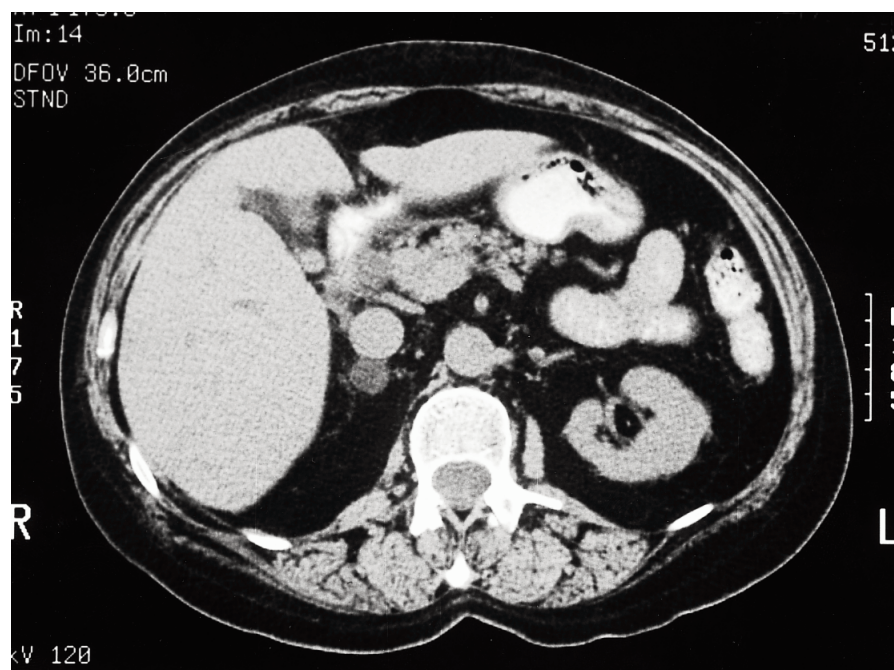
Adrenal CT scan from a patient (no. 27) demonstrating a 2-cm mass in the right adrenal gland thought to be typical of an aldosteronoma.
